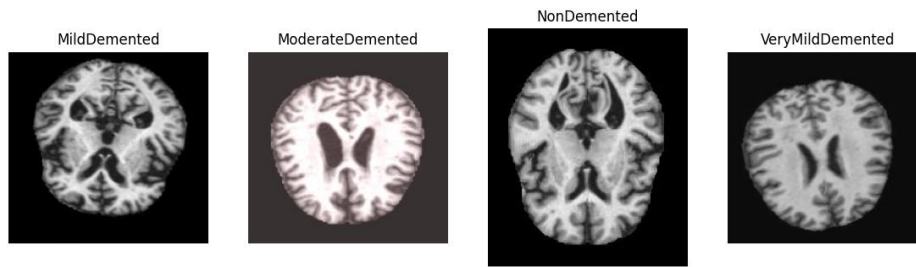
Sample MRI images across the four dementia stages
